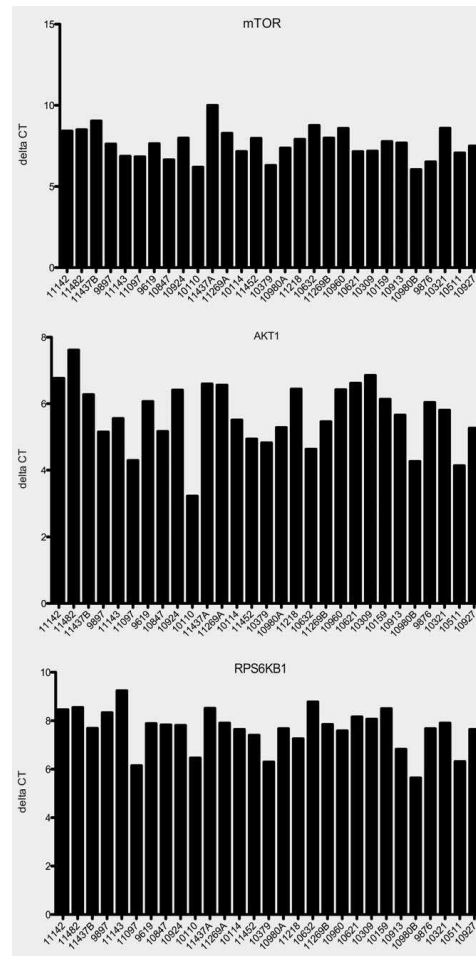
Delta CT values for mTOR pathway members RPS6KB1, AKT1 and mTOR sorted to Everolimus response with best responders on the left to resistant tumors on the right.
